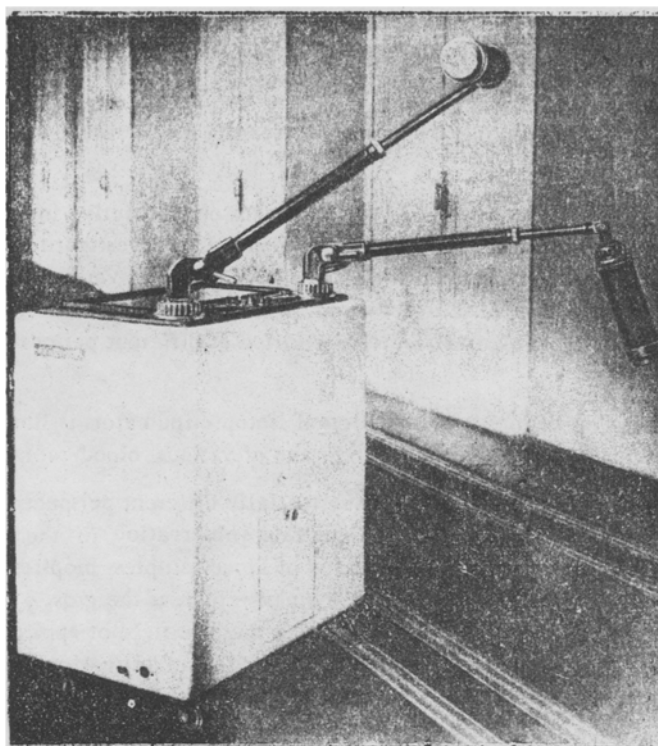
External appearance of the first model of the two-channel radiograph.
